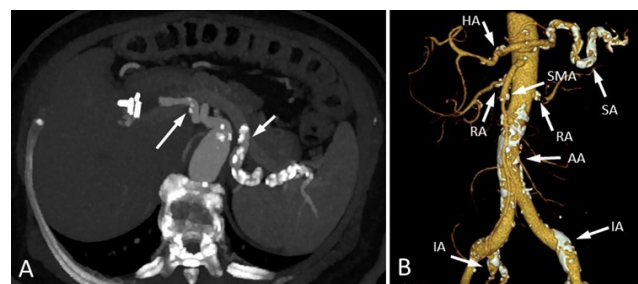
A 70-year-old female patient underwent an AA CTA exam for the suspicion of RA stenosis. (A) Axial plane maximum intensity projection (MIP) CT image shows calcified plaques in HA (long arrow) and SA (short arrow). (B) Coronal plane volume rendering technique (VRT) image demonstrates multiple calcified plaques in HA, SA, SMA, RA, AA, and IAs. AA: Abdominal aorta, HA: Hepatic artery, IA: Iliac artery, SA: Splenic artery, SMA: Superior mesenteric artery
